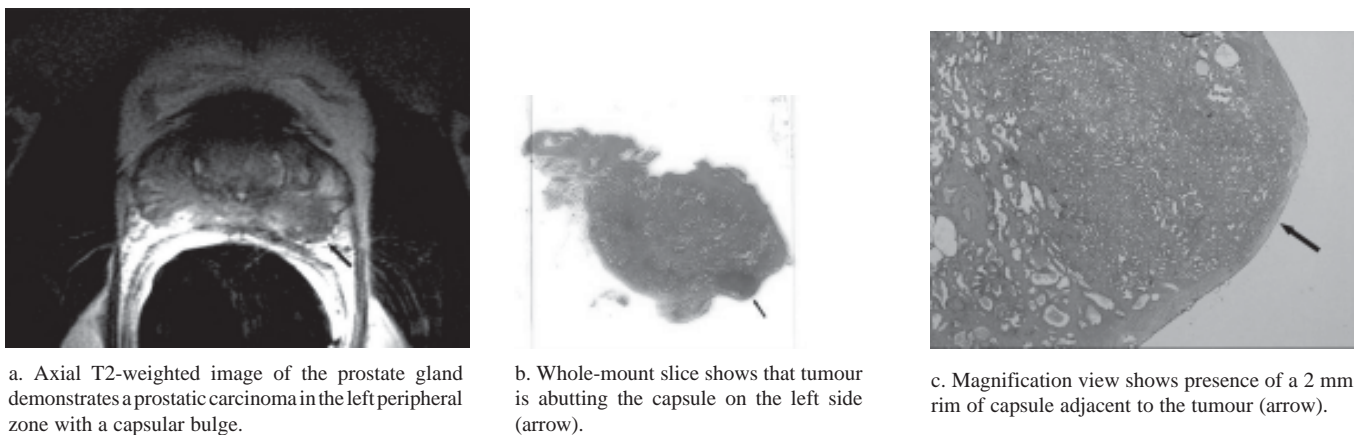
False positive depiction of extraprostatic extension by endorectal magnetic resonance imaging (MRI).
